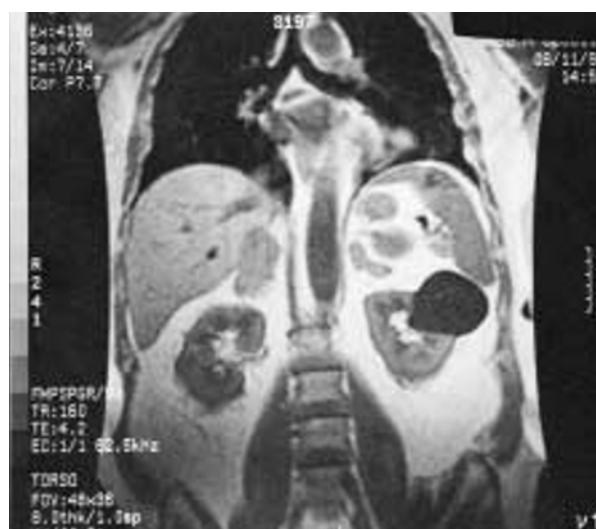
MRI reporting bilateral enlargement of the adrenal glands with irregular nodular aspect.
